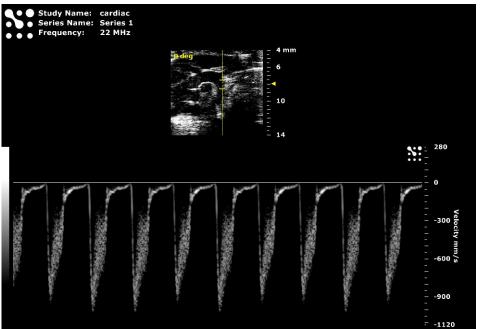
Flow Distribution display in PW Doppler Mode on the Descending Aorta
